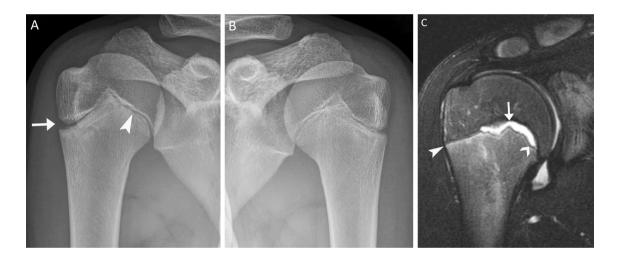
Little Leaguer's shoulder. A, B Frontal radiograph of the symptomatic right shoulder from a 13-year-old boy who is a baseball pitcher and with 3 months of symptoms shows asymmetric widening (arrow) of the lateral portion of proximal humeral physis when compared to the normal medial portion (arrowhead). Note the subtle subjacent metaphyseal sclerosis of the right shoulder, which is asymmetric when compared to the asymptomatic left shoulder (B).
